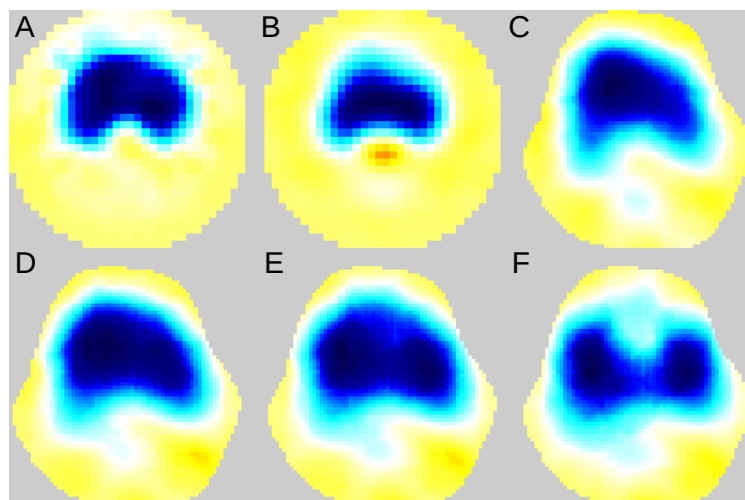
Reconstructed TD-EIT images of ventilation (inspiration minus expiration). *A*: Sheffield backprojection (circular model); *B*: GREIT using circular homogeneous model[1]; *C*: GREIT using conforming FEM model from CT (fig. 2) with homogeneous conductivity; and *D–F*: GREIT using conforming FEM model with lung-to-background conductivity ratio of 0.75, 0.50 and 0.25, respectively. All images represent the same measurement data and are normalised to the same range.
